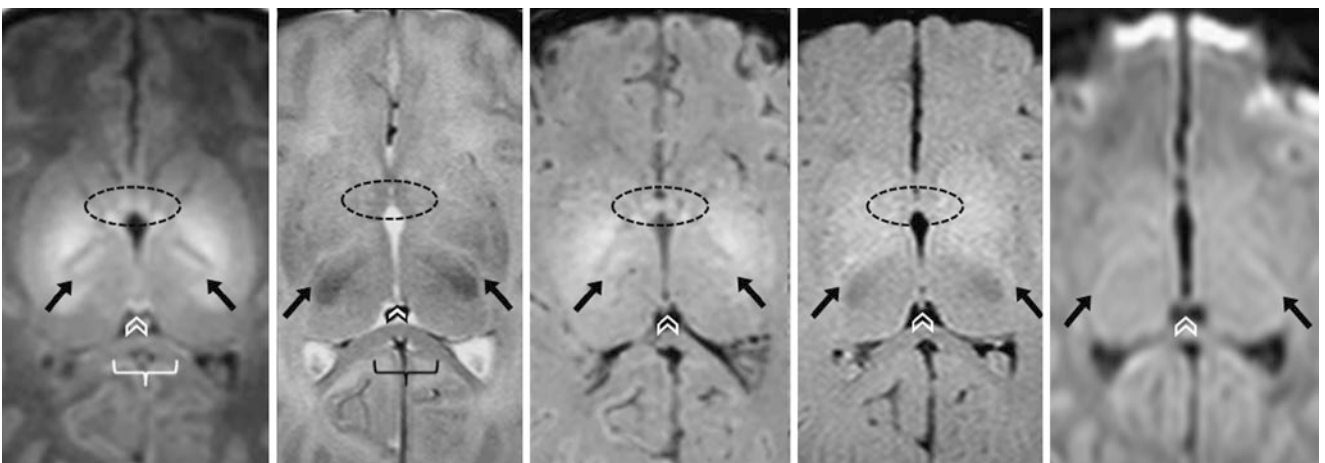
A different 4-day-old term neonate had a normal 3T MRI with GE T1WI (left), SE T2WI (left middle), SWI (middle), FLAIR (right middle), and DWI (right). The HC (chevrons) and PLIC (arrows)
